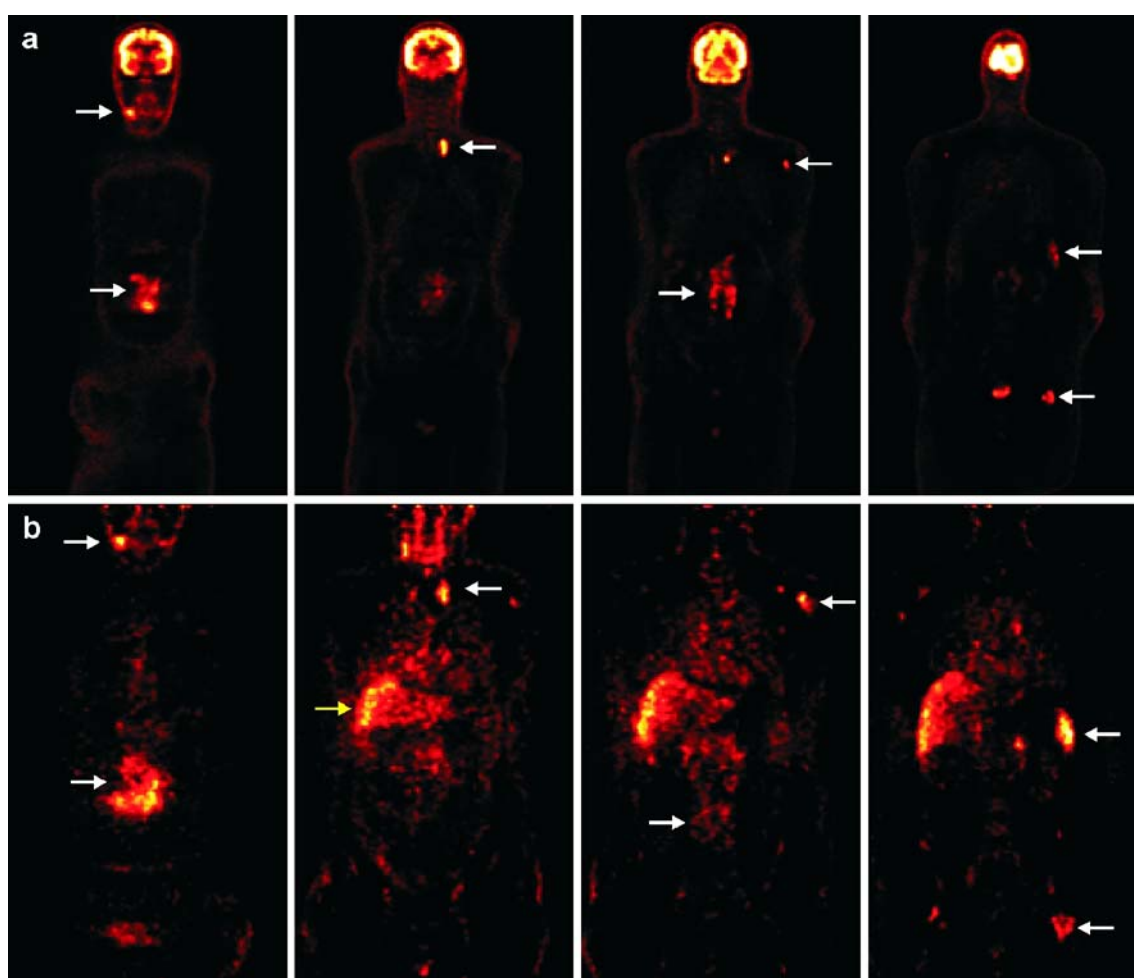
a [^{18}F]FDG-PET scan of the NHL patient. Coronal images from anterior (left) to posterior (right), with visualisation of cervical, mediastinal, left caput humeri, splenic, para-aortic and inguinal lymphomas. Localisations are indicated by white arrows. b ^{89}Zr -Zevalin immuno-PET scan 96 h p.i. of the same NHL patient. Coronal images from anterior (left) to posterior (right); slices
